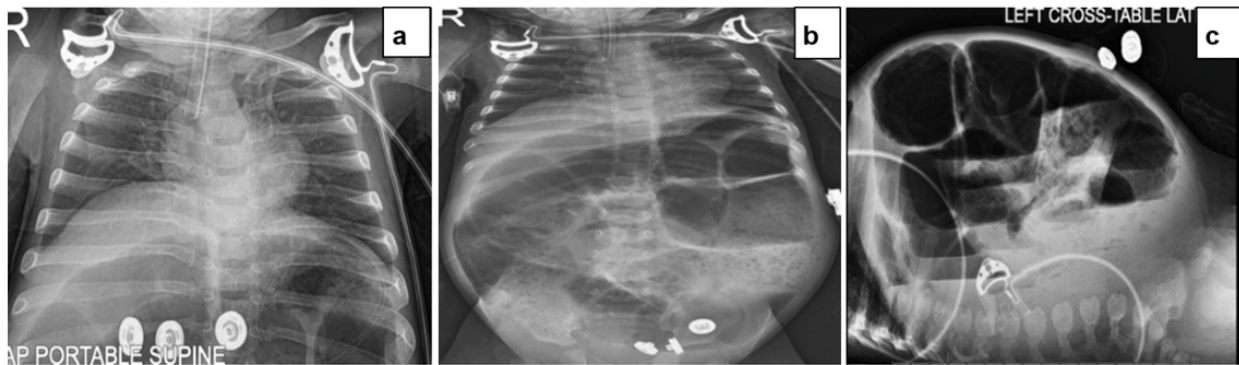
a: Chest X-ray showing an endotracheal tube in a low position; b: Anterior-posterior abdominal X-ray showing small bowel obstruction; c: Left lateral Abdominal X-ray showing marked distention of the whole length of the bowel loops.
